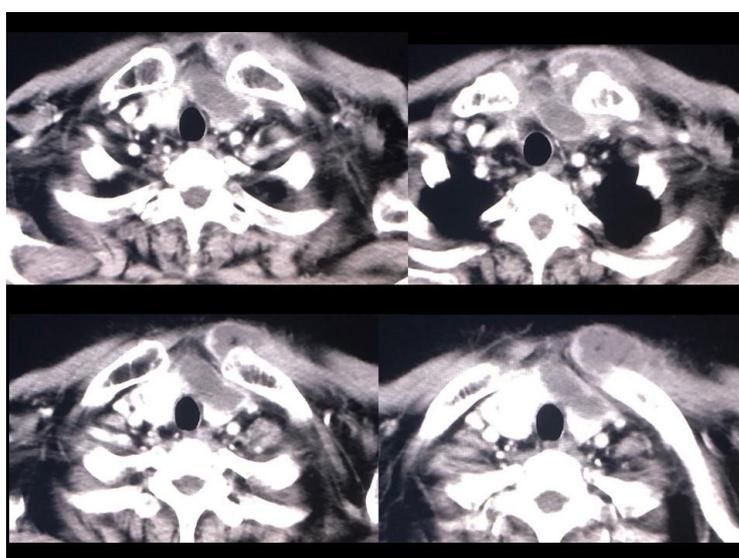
Chest computed tomography (CT) on arrival Chest CT depicted fluid collection with ring enhancement just in front of and behind the left sternoclavicular joint. The proximal side of the clavicular bone became osteolytic due to osteomyelitis
